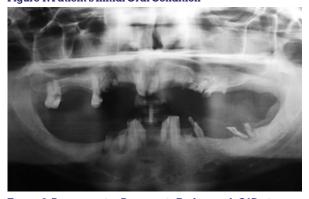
Pre-operative Panoramic Radiograph Of Patient
